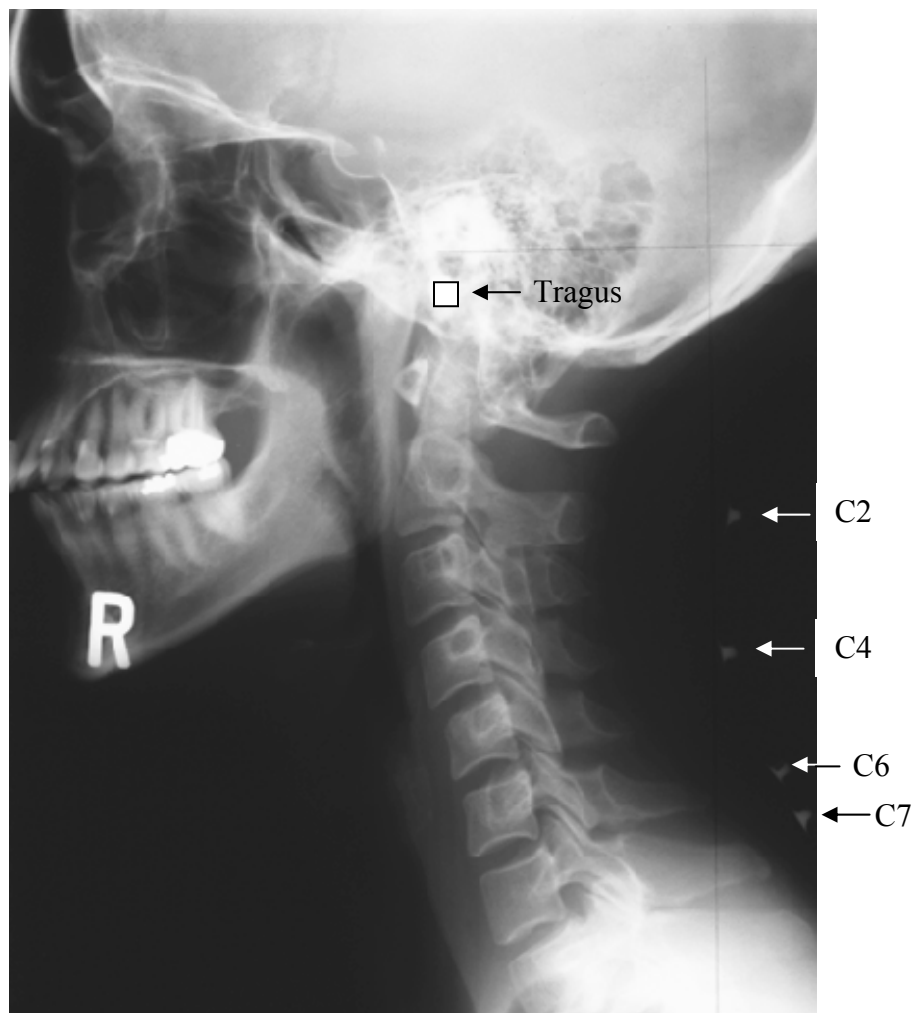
Radiographic image of the craniocervical posture (arrow indicate markers)
